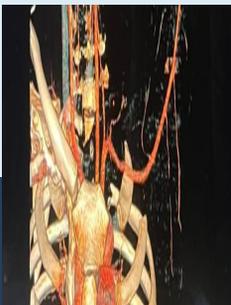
CTA 3D reconstruction of patient showing left first rib fracture abutting subclavian artery
